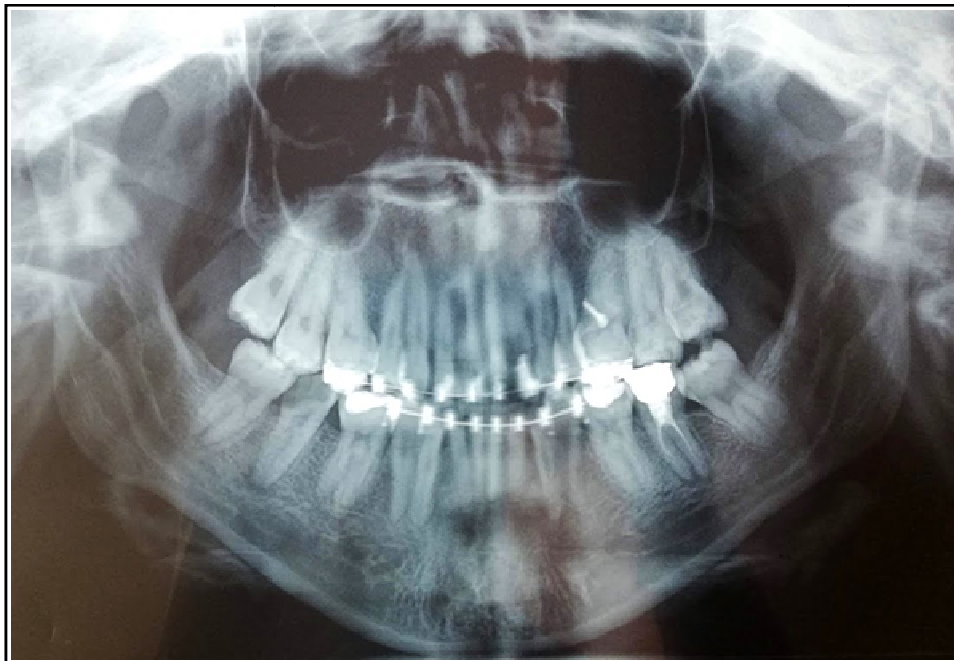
Panoramique Radiograph
